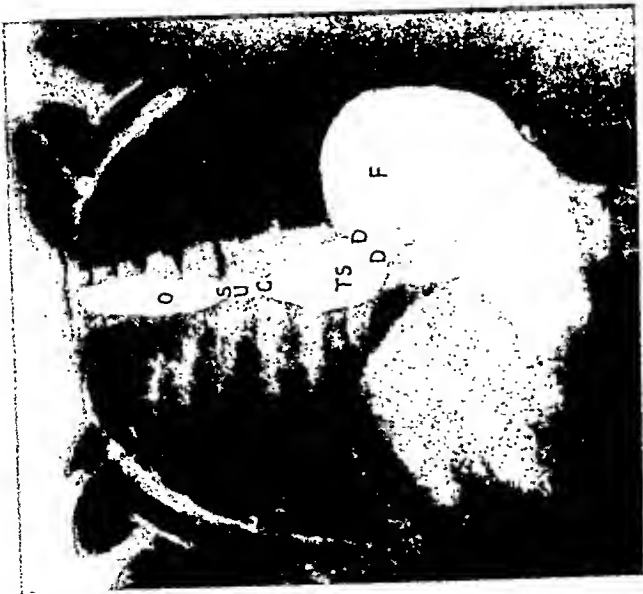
Radiograph of oesophageal ulcer with congenitally short oesophagus and diaphragmatic hernia in a child of three. O, oesophagus; S, spasm; U, niche of ulcer crater; C, cardiac sphincter; TS, thoracic portion of stomach; DD, level of diaphragm; F, fundus of stomach. (After Haroen and Gerlings, 1934.)
